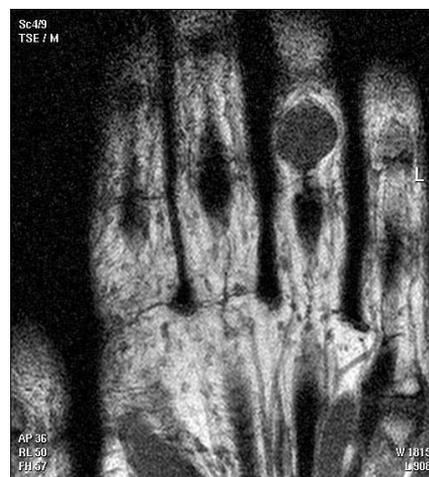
33-year-old woman with soft tissue swelling in fourth finger flexor aspect. In non-contrast enhanced T1 weighted magnetic resonance image there is well-defined, hypointense lesion adjacent to the tendon.
